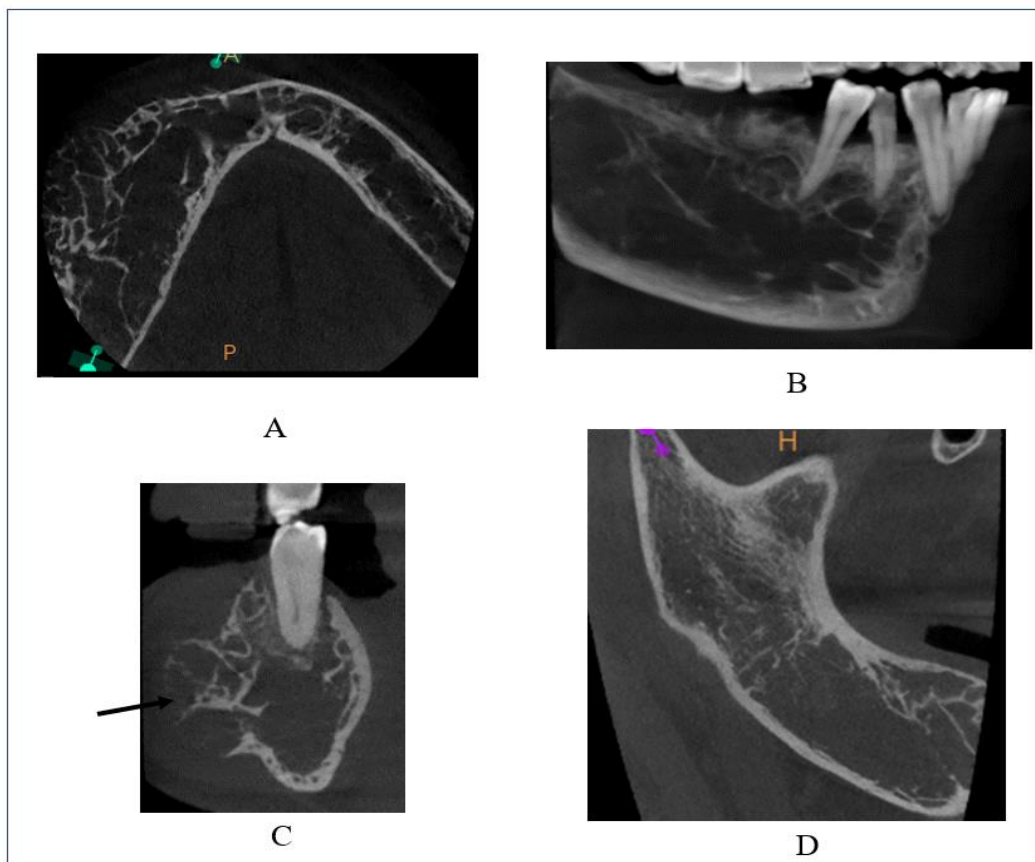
Cross sectional CBCT images of right side of mandible. A: Axial image of mandible (at level of mid-alveolar region); B: Oblique sagittal image; C: Coronal image in 45 degree region (arrow showing buccal expansion, thinning with interruption); D: Oblique sagittal image of right ramus.
